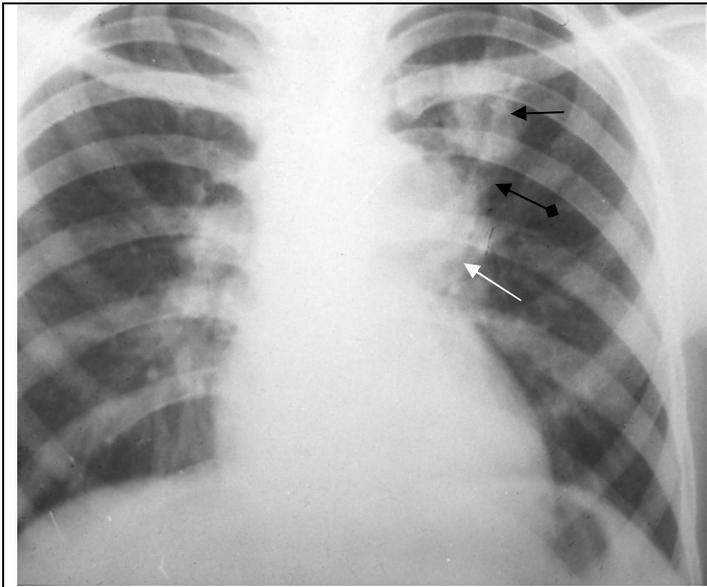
The frontal chest radiograph. In the upper department of the left lung a roundish shadow with not absolutely distinct contours, non-gomogenous, and highly intensive (black arrow). The left hilum is enlarged; its external contour is convex (arrow with a rhombus). Between a shadow and a lung root there is intensification of lung pattern (white arrow). Tuberculous primary complex in the left lung in a phase of consolidation and calcification.
